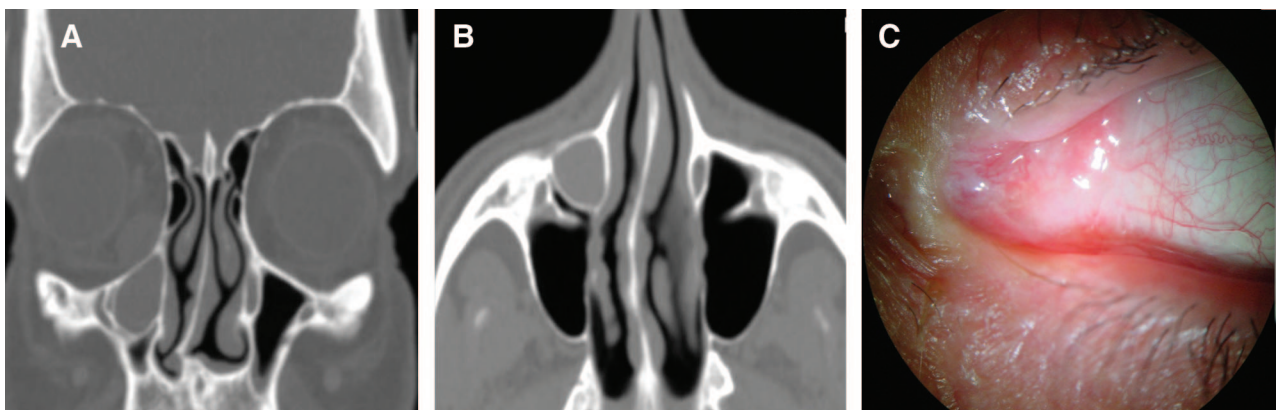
Case 2, a 46-year-old man. A, Coronal CT shows enlargement of the left nasolacrimal duct (19 mm in diameter). B, Axial CT shows left maxillary dacryocystocele. C, Left lacrimal puncta agenesis.
